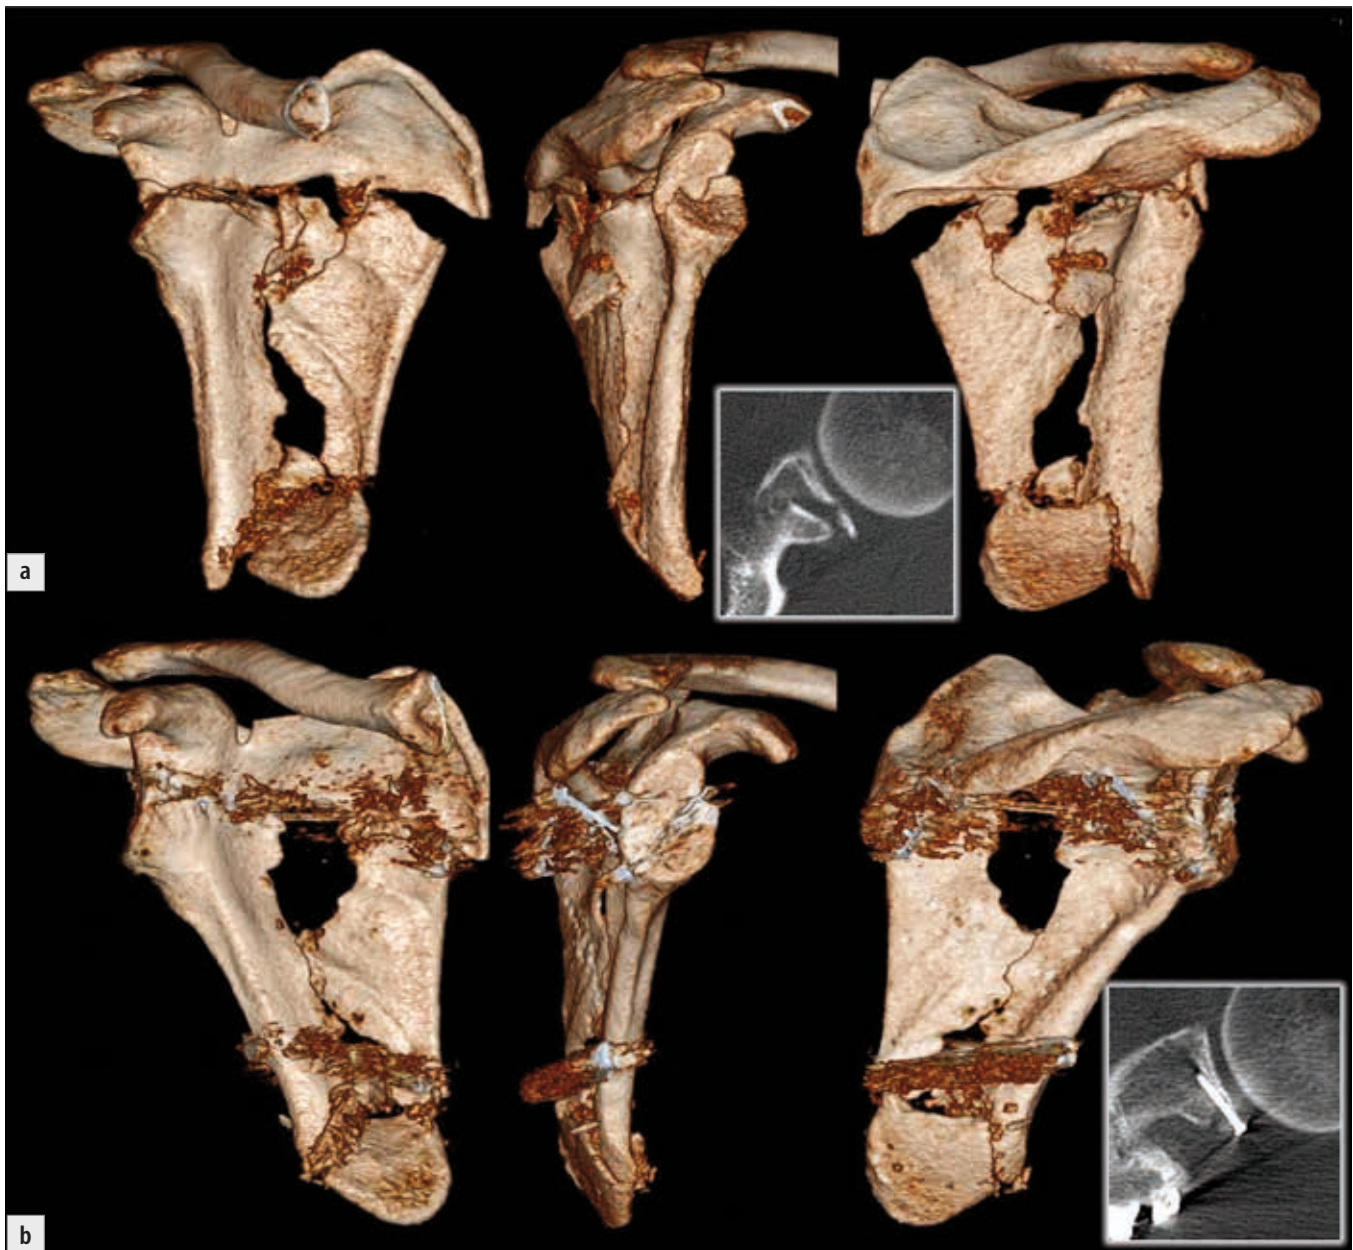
The fracture on 3D CT reconstructions: a) before operation; b) after operation.
